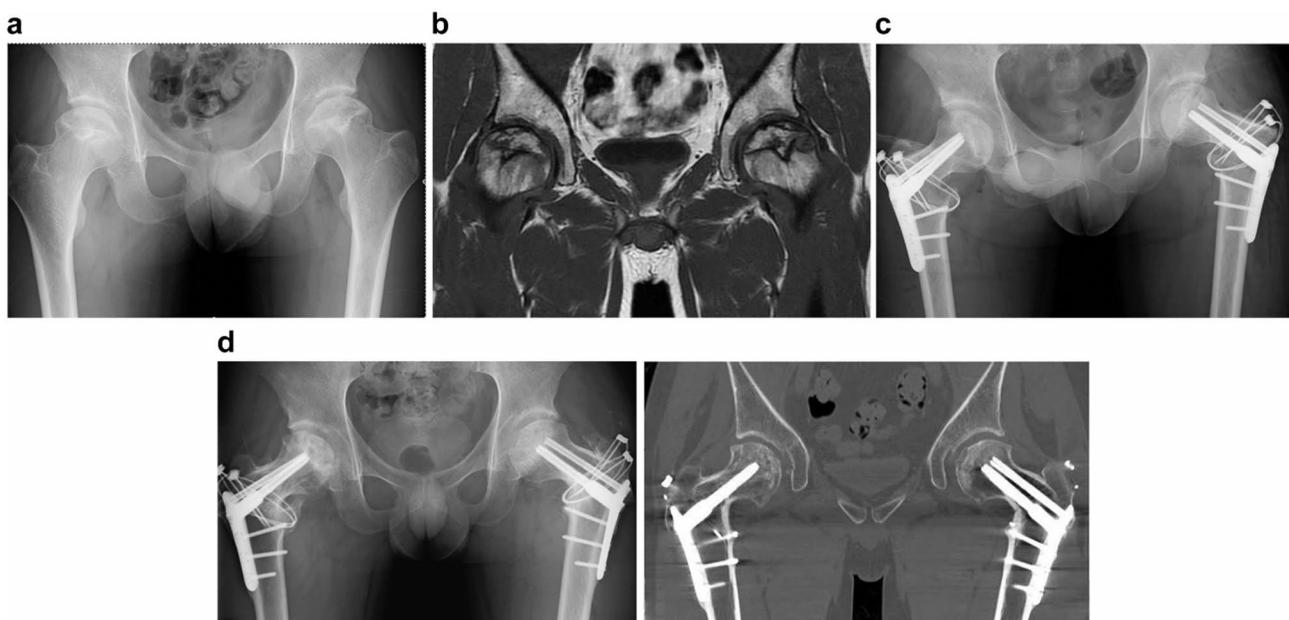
a. Preoperative X-ray. Frontal view of both hip joints Japanese Investigation Committee Classification Type C 2/C2 Stage 3b/3b. b. Preoperative magnetic resonance imaging. Central slice of the femoral head. c. Immediately after surgery. Surgery time: Total 3 h30 m. Blood loss: 310 ml. d. Frontal view and computed tomography coronal section of both hips 1.5 year post-op. Joints preserved. Intact ratio on the right and left improved from 0–51% and 0–47%, respectively
